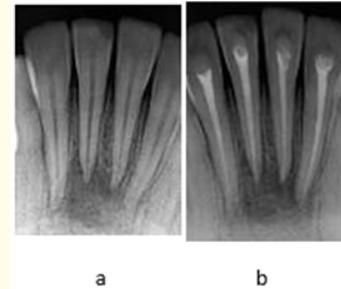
a) Post Operative Radiograph, b) Pre Operative Radiography
